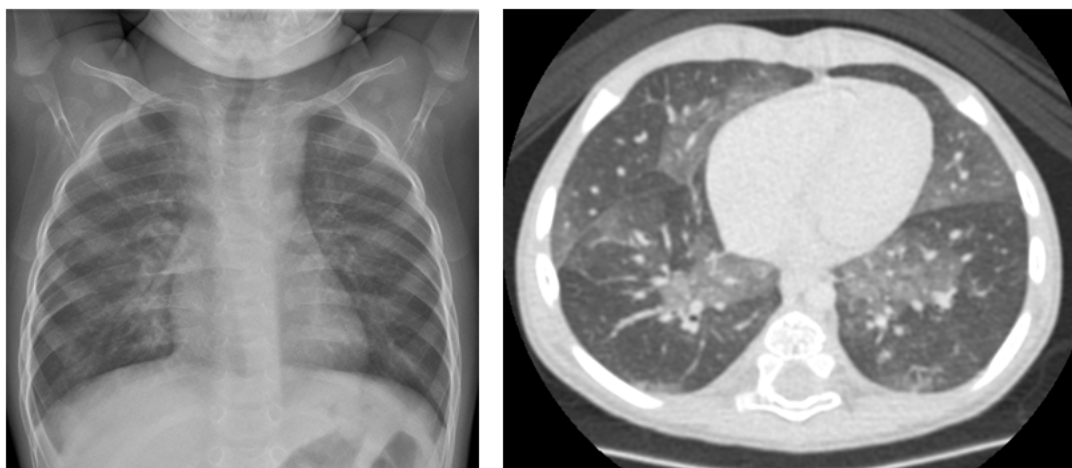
Chest X-ray and CT of a four-month-old infant with typical appearance of NEHI. The chest X-ray is not specific, showing discrete central ground-glass opacities and peripheral hyperinflation. An inspiratory high-resolution CT scan shows sharply defined areas of ground-glass opacification along mediastinal borders, most prominently in the right middle lobe and lingual.
